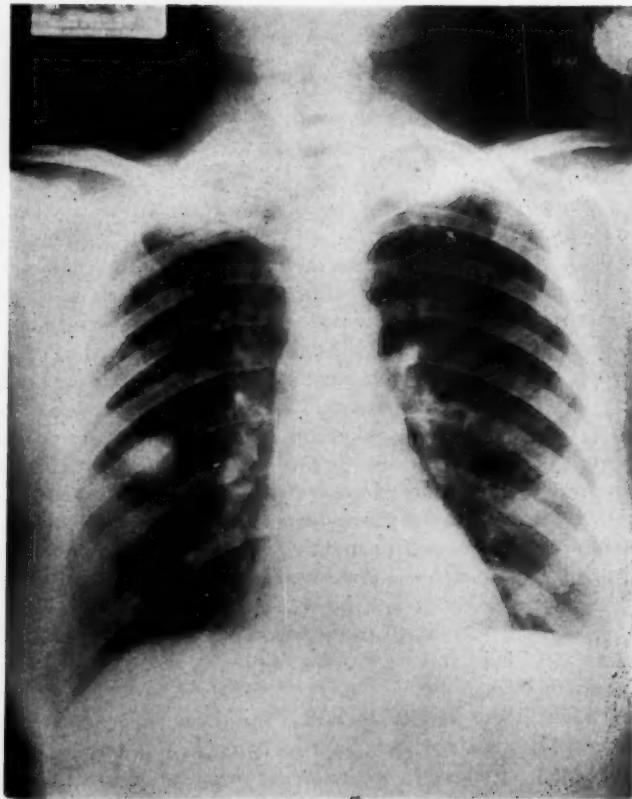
Case No. 4. Chest x-ray made on admission. The bilateral apical infiltration and the nodular lesion in the right mid lung field may be considered a variant of the usual appearance of the roentgenograms of the chest in Wegener's granulomatosis.
